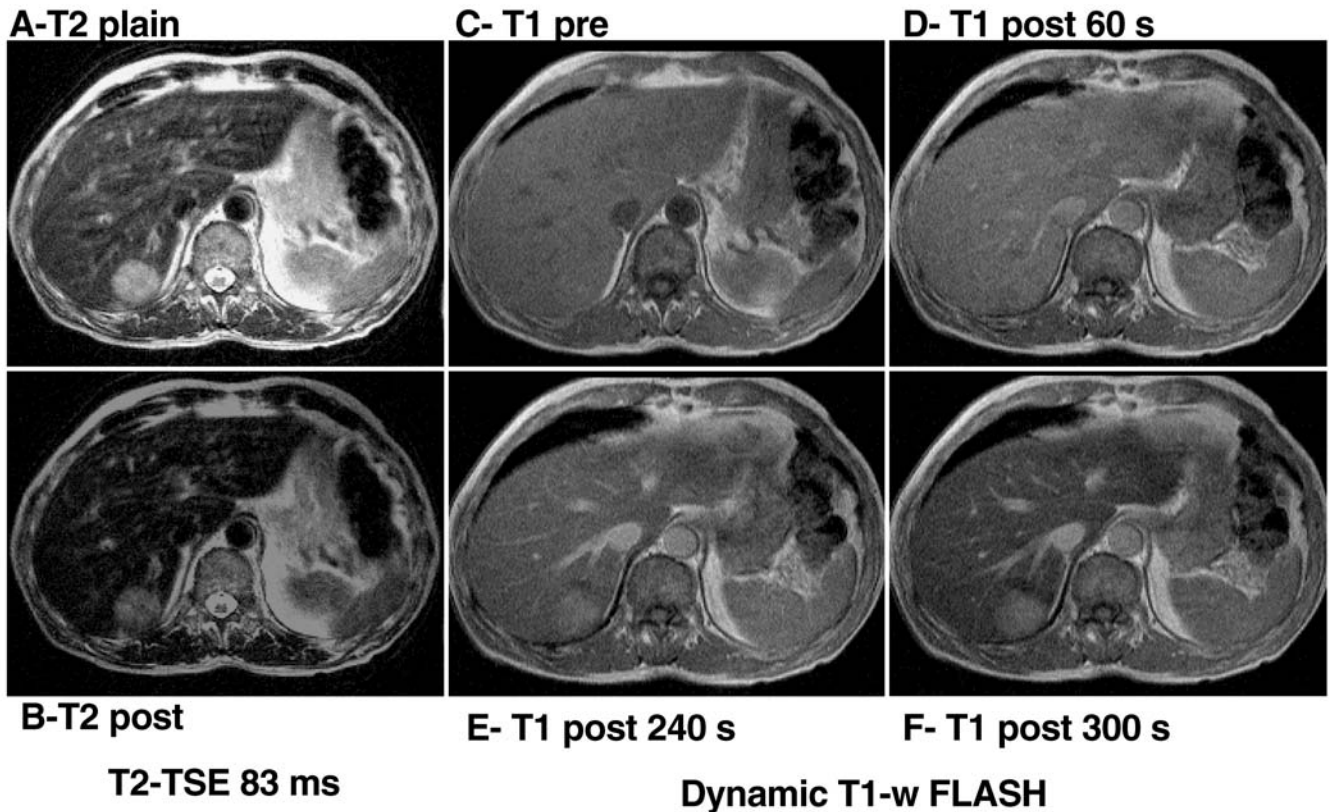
Hepatocellular carcinoma: dynamic T1 and accumulation-phase MRI. T2-weighted TSE images (a plain and b post) show decreased contrast and conspicuity on the enhanced image (b) because of a decrease in signal intensity within the lesion due to uptake of contrast material. Dynamic ferucarbotran-enhanced T1-weighted fast low-angle shot (FLASH) images (c pre, b 30 s, d 60 s, e 240 s, and f 300 s) show marked and persistent enhancement within the lesion and vessels due to the subfraction of small particles providing a blood-pool equivalent angiographic effect
